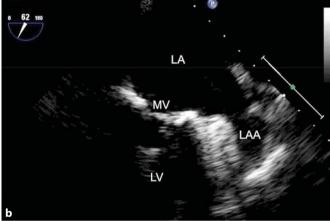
Transesophageal echocardiogram. a Midesophageal two-chamber view showing the presence of a thrombus (arrow) in the LAA. b Midesophageal two-chamber view after 3 weeks of treatment with apixaban showing the complete resolution of the thrombus in the LAA. LA = Left atrium; LV = left ventricle; MV = mitral valve.
